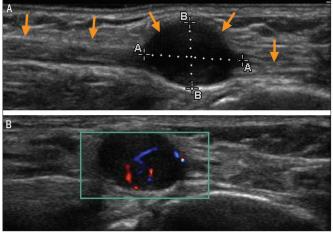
(A) Long-axis view of the posterior tibial nerve (arrows) showing the nerve tumor as a hypoechoic soft tissue mass within the nerve sheath. (B) Oblique short-axis view of the soft tissue mass showing vascularity on color Doppler ultrasound.
